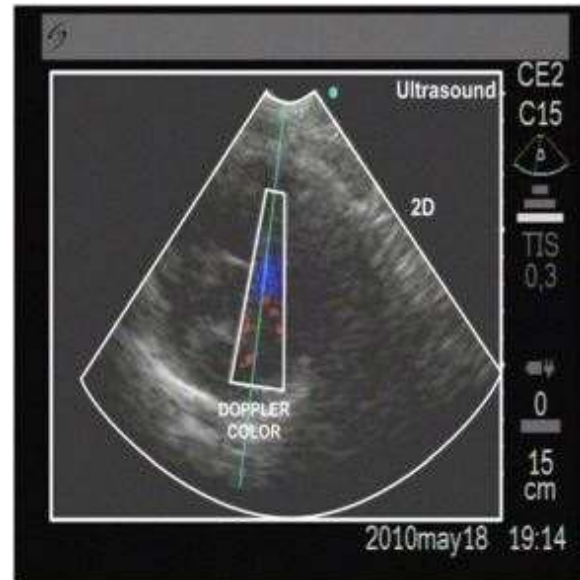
Section of the ultrasound in the 2-D modes.
